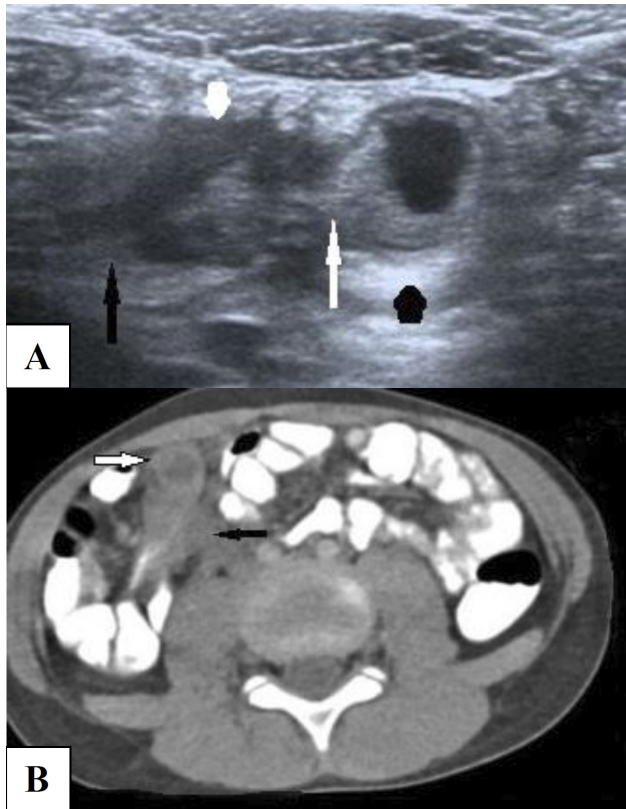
A. An ultrasound view shows the appearance of a blind-ending and thick-walled bowel segment (white arrow) in continuity with the terminal ileum (black arrow) surrounded by soft tissue hyperechogenicity (black arrowhead) and free fluid (white arrowhead). B. Contrast-enhanced abdominal CT axial image shows a blind-ending intestinal structure (white arrow) with reactive lymph nodes (black arrow).
